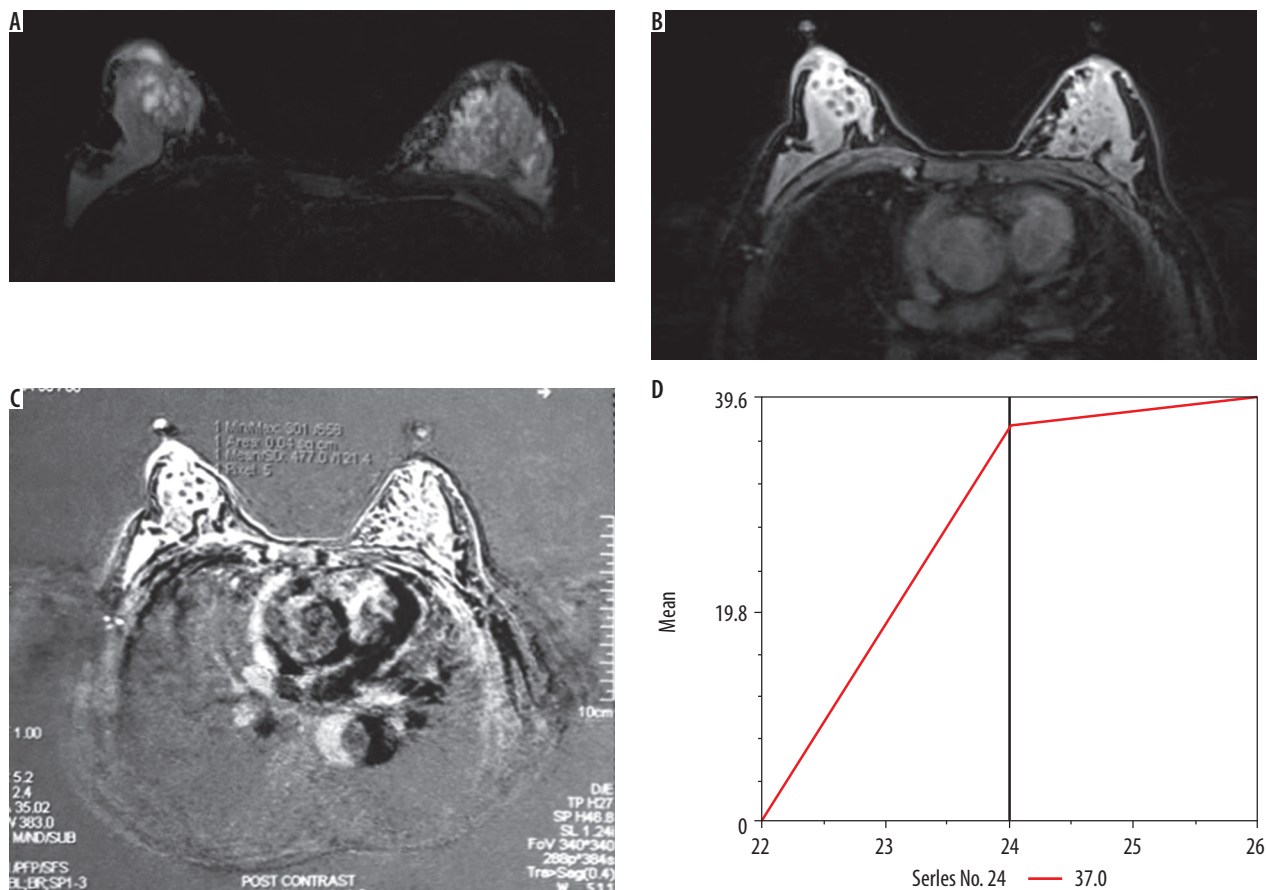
Magnetic resonance imaging breast in a case of mastitis in 38-year-old woman. A) Axial STIR image showing an ill-defined heterogeneously hyperintense signal intensity lesion seen in the right breast. B) Axial post contrast fat sat T1WI showing heterogenous enhancement of the lesion more on peripheral aspect. C-D) Time signal intensity curve of the mass showed type II kinetic curve (plateau)
